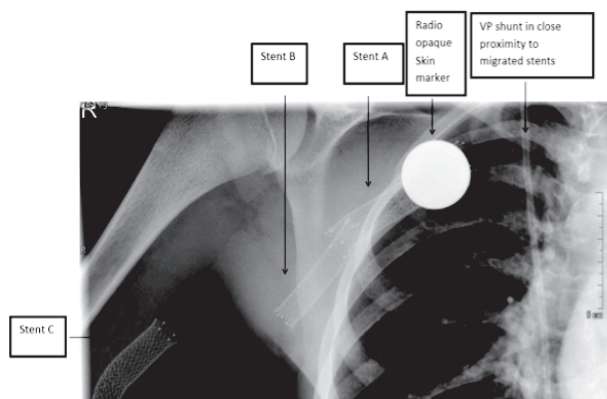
Chest X-ray Revealing the Position of the Migrated Stents
